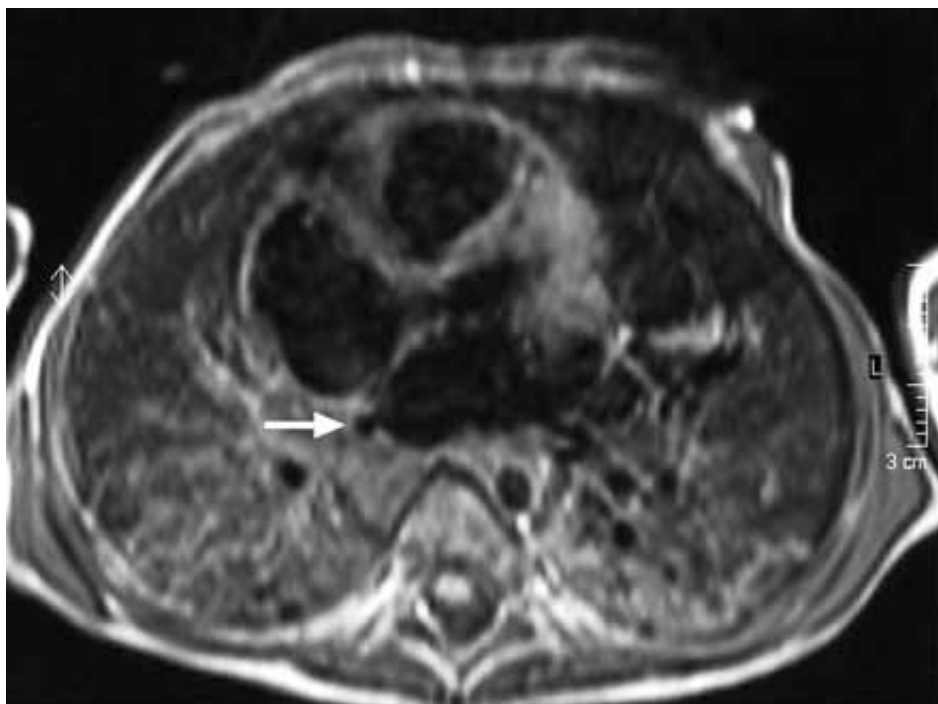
Magnetic resonance image scan of heart and lungs of patient 1 with the atretic remnant of the right pulmonary veins (white arrow).
